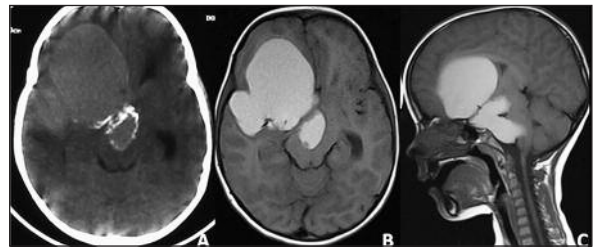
Initial axial NECT (A), axial (B) and sagittal (C) T1W MR images shows a multilobulated, predominantly cystic including hyperdense proteinaceous fluid and partially calcified tumor.
